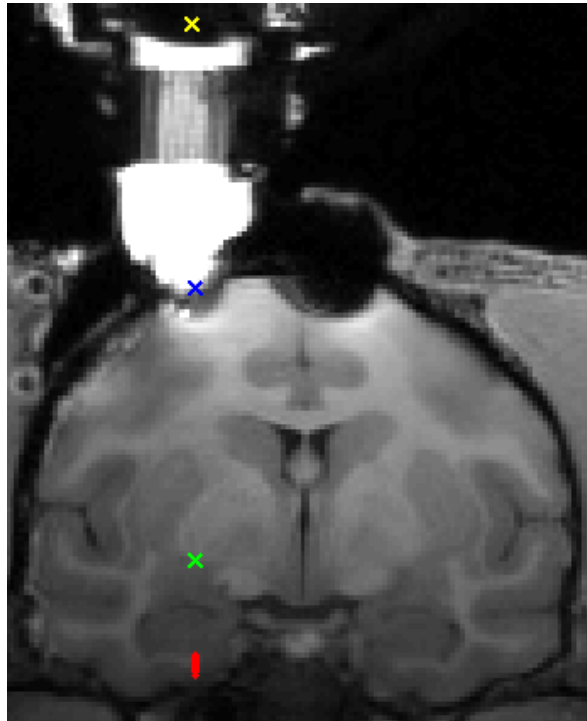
Display of estimated electrode position on T1-weighted MRI slice. A live display of the position of all electrode contacts (red) is generated in MATLAB through custom code for serial communication with the microdrive controller (FHC, Inc.). Yellow: top-center of chamber. Blue: location of top of dura mater. Green: tip of the steel guide cannula. Red: all electrode sites. Live zooming and panning is made possible through the MATLAB plotting interface, which is especially useful for zooming in on the 13 electrode sites in red.
